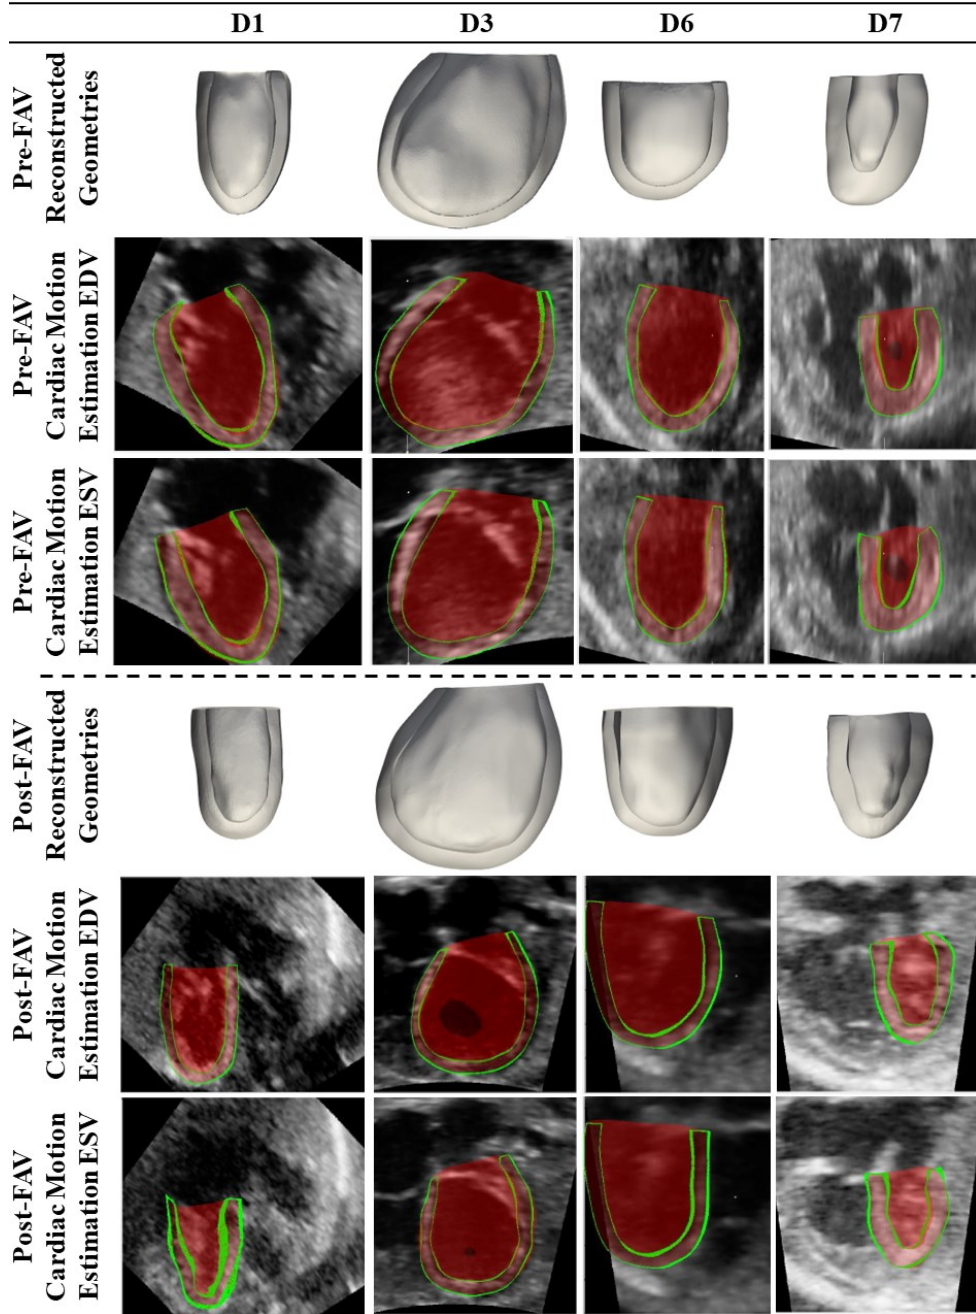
Patient specific geometries, reconstructed from pre- and post-FAV echocardiographic data, with the reconstructed geometries superimposed onto associated echo image, to depicting cardiac motion estimation results, for all patients pre- and post-FAV at EDV and ESV time points. The green outline highlights the geometry proportion close to current image plane.
